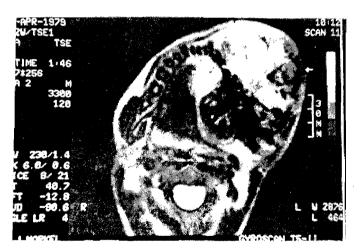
Magnetic resonance imaging showing extent of tumour mass
